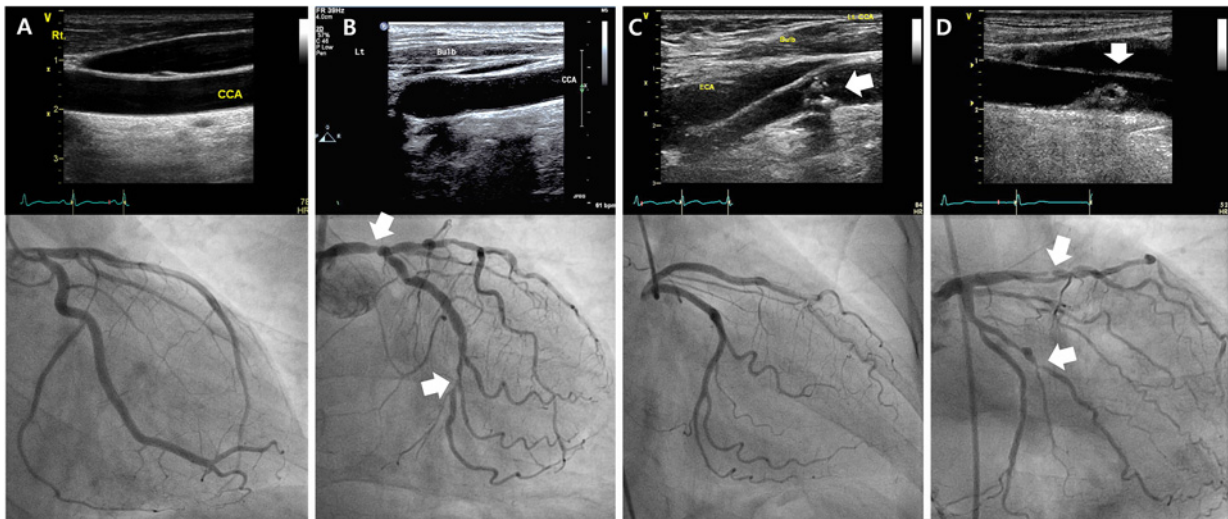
Representative carotid ultrasonography and coronary angiographic findings of each group (A, group I; B, group II; C, group III; D, group IV). Arrows indicate coronary artery stenosis or carotid plaque.
